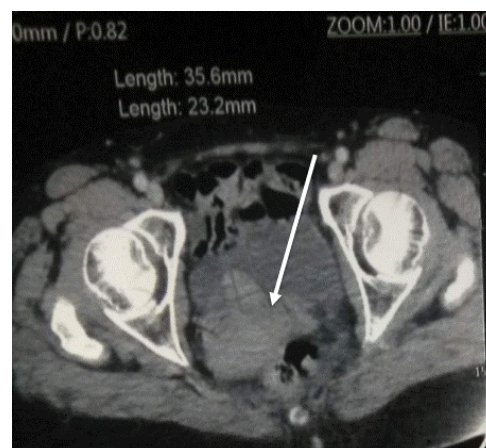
Axial excretory phase CT urography showing diffuse irregular mural thickening along right posterolateral wall of bladder (T2-T4aN0M0 MIBC). Courtesy of Hopital General de Grand Yoff.
